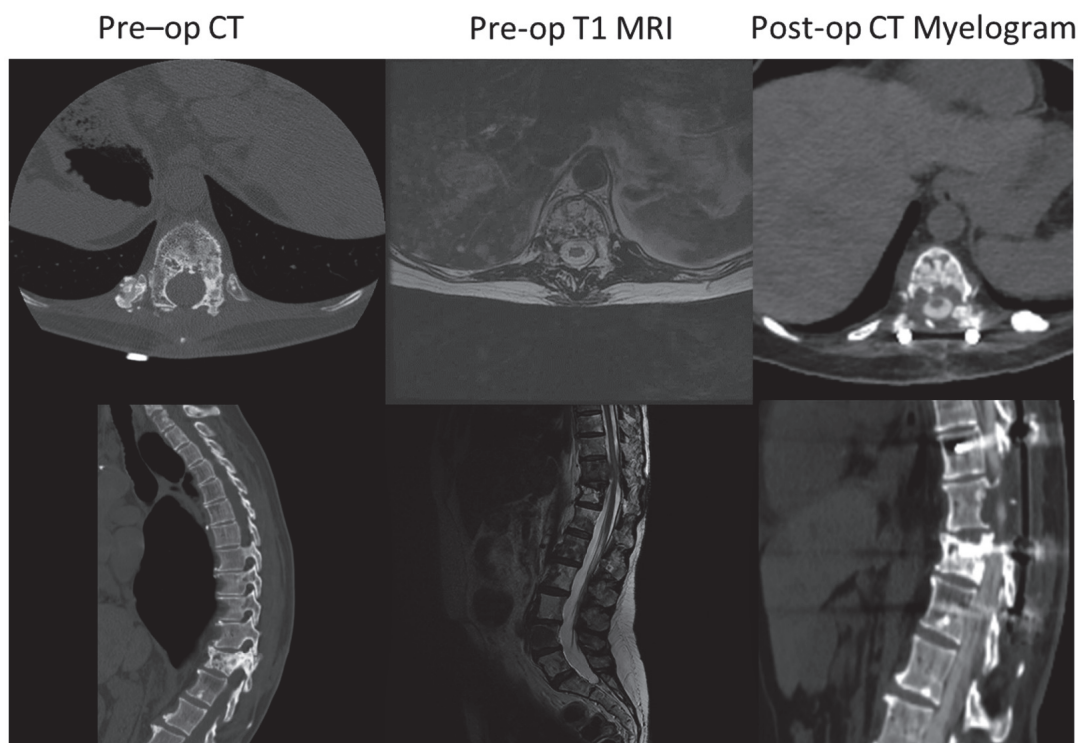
Patient 3: Clinical course – Patient with T11 circumferential epidural disease (Bilsky score 3). Preoperative CT and MRI show extensive epidural disease. Postoperative CT myelogram shows T8 – T11 bilateral instrumented fusion with laminectomy with reduction in tumour volume and definition of the spinal cord.
